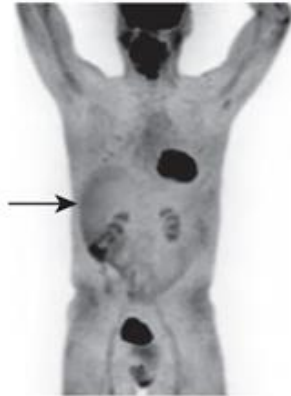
Nonattenuated corrected maximum intensity projection image from an FDG PET scan. Arrow points at the liver surface, which appears to have more photon counts than the deeper portions of the liver.
